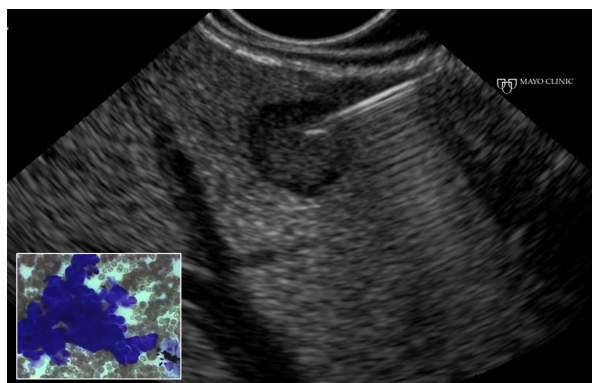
Endoscopic ultrasound-guided fine needle biopsy of a hypoechoic hepatic lesion first seen on non-invasive imaging; cytopathology was consistent with metastasis from pancreatic ductal adenocarcinoma (inset).
